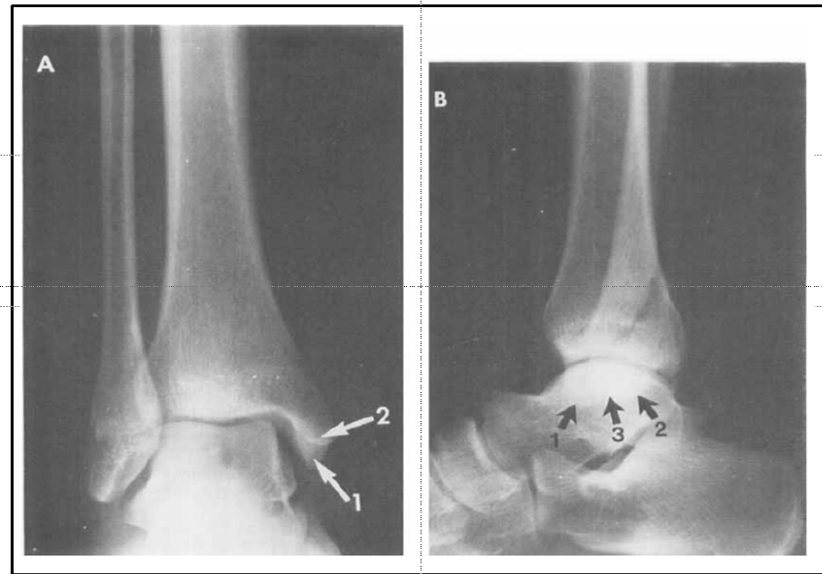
Radiographic image of the medial malleolus; A, anteroposterior view; B, lateral view; 1, anterior colliculus; 2, posterior colliculus; 3, intercollicular groove (Pankovich and Shivaram, 1979b).
